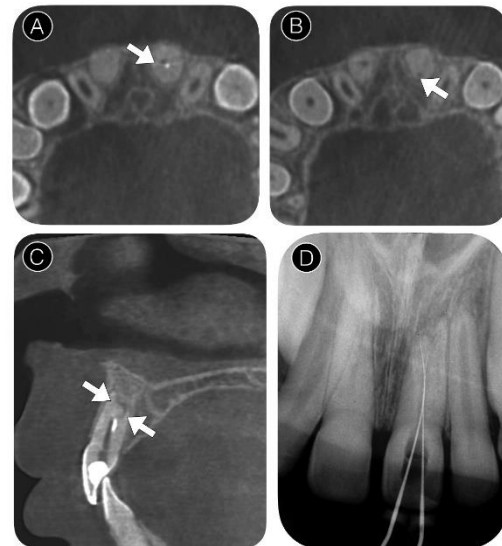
(A) Axial CBCT section showing the canal in the buccal position. (B) Axial CBCT section showing the palatal canal. (C) Sagittal CBCT section showing the bifurcation region. (D) Radiograph for confirmation of the working length.
